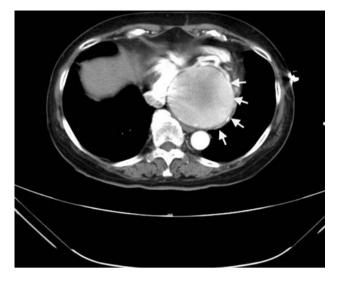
Computed tomography (CT) image. The image shows a giant mass (*white arrows*) enhanced by contrast in front of the descending aorta. The wall of the aneurysm contains calcification spots. A tortuous vessel courses ventrally to the aneurysm
